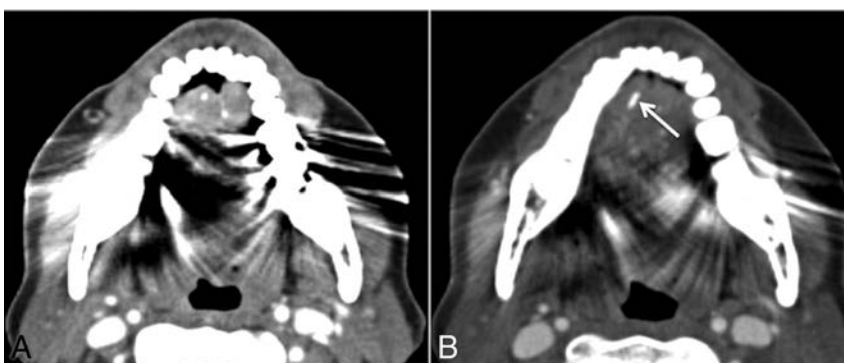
Potential false-negative. A, Axial contrast-enhanced CT. Significant streak artifacts in the floor of the mouth due to dental amalgam. B, Single section inferiorly with windows adjusted manually, revealing an obstructing calculus (arrow) in the right anterior submandibular duct. One should be cautious when analyzing the floor of the mouth because this is a classic location for obstructing submandibular duct calculi and can easily be missed.
